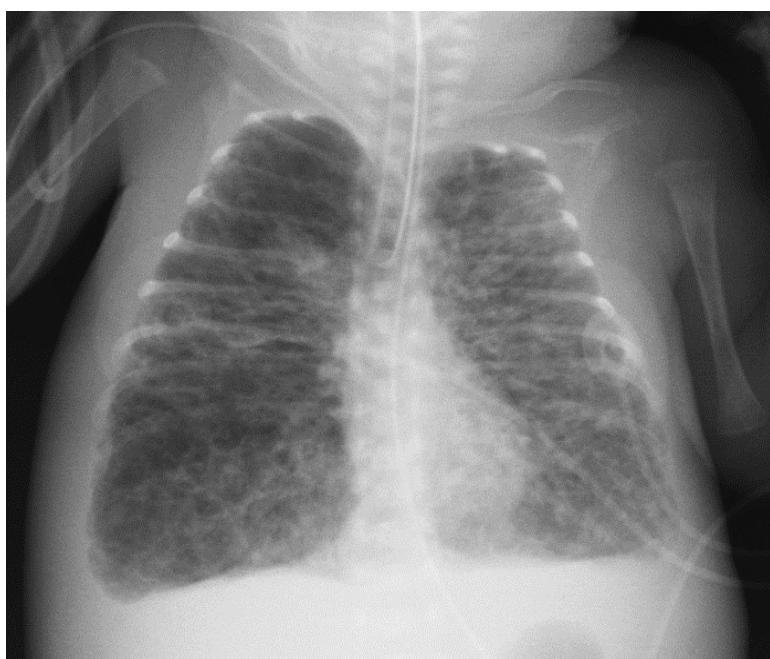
2: Day 23 Chest x-ray with bilateral cystic lung fields and hyper-expanded lung fields Resulting in small cardiac silhouette with flattened domes of the diaphragm.
